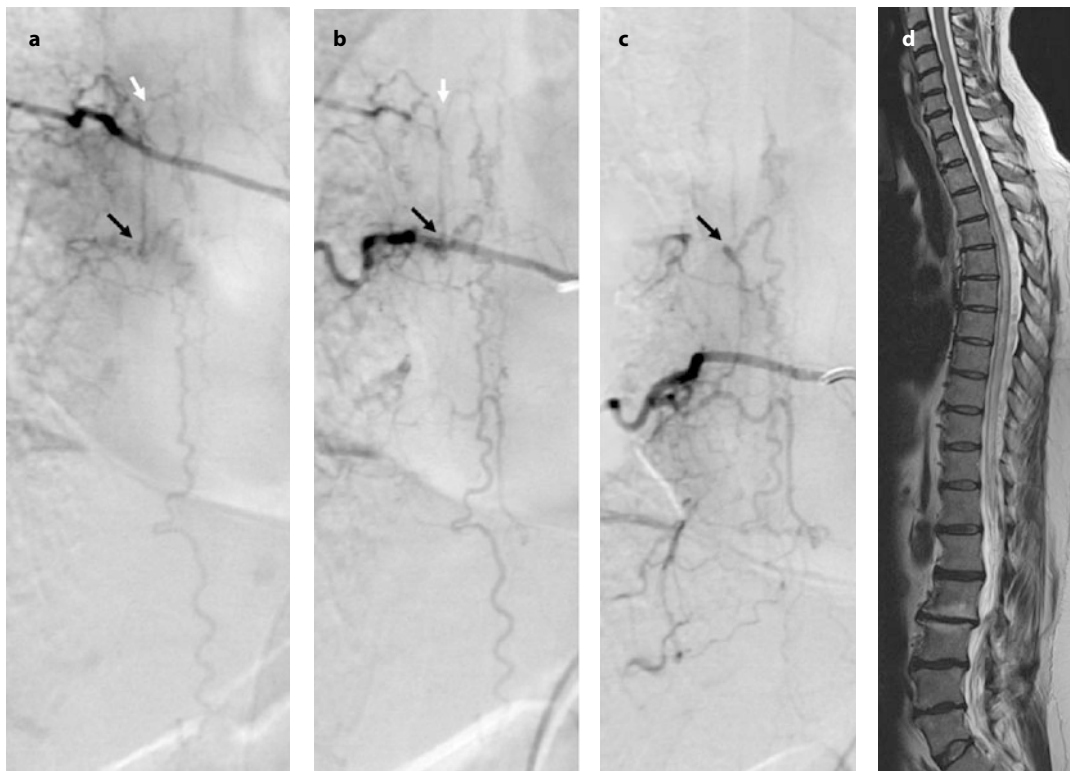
Dural arteriovenous fistula (type I) with multiple feeders. The fistula is fed by left T6 (a) T7 (b) and T8 (c) thoracic radiculomedullary arteries. The main arteriovenous shunt is in T7 (black arrow) and is supported by adjacent levels. An additional small feeding vessel (white arrow) penetrates the dura at the T6 level and contributes to the venous outflow. T2 sagittal MRI (d) shows congestive myelopathy with spinal cord edema from T4 to the conus medullaris
